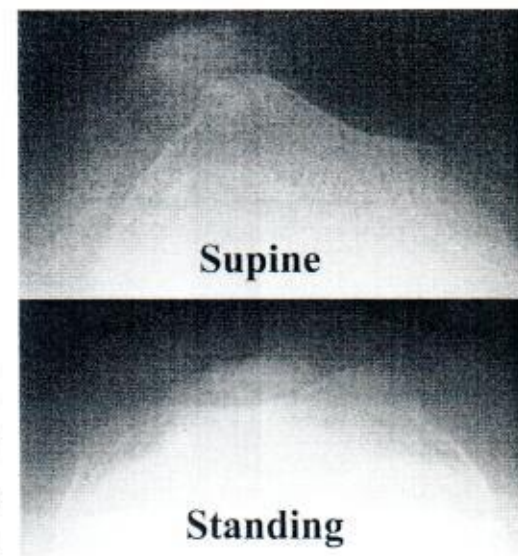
Attempts to obtain axial radiographic views in a patient with congenital patellar displacement in the supine position. There is no patellar displacement in the standing position, which led to an alteration in the planned surgical treatment
